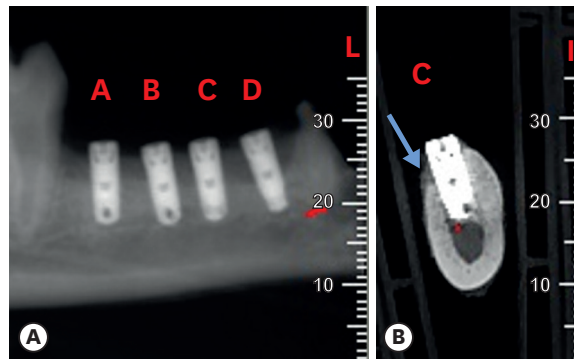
X-ray tomography at 1 month (S100%, intact socket). (A) Mesio-distal view of 3 implants. (B) Linguo-vestibular view of an implant with mineralized bone cortical allograft particles and a membrane. The blue arrow indicates the buccal wall with limited height and widthwise bone resorption.
